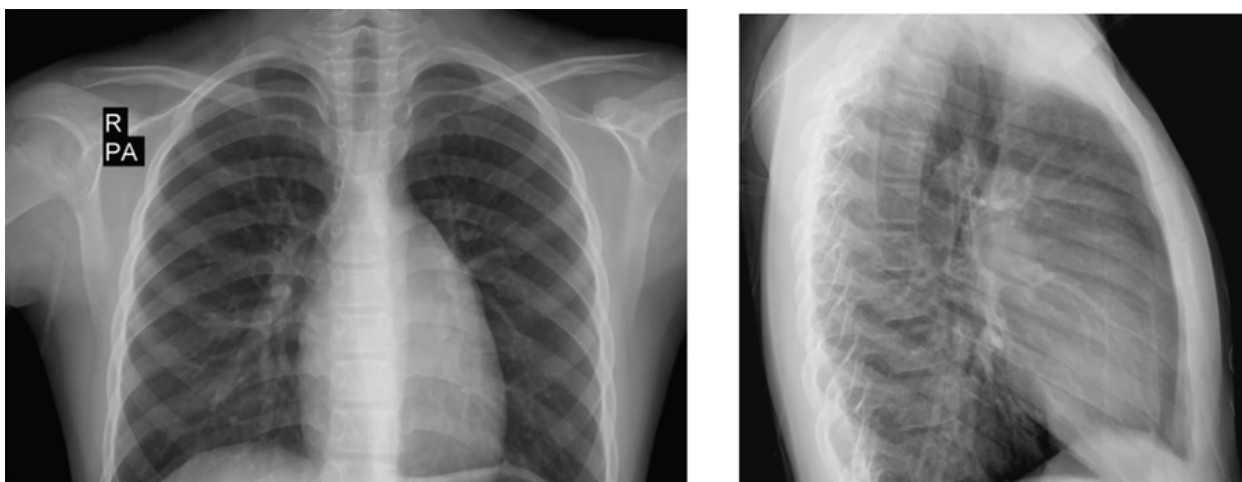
Chest X-Ray (AP-lateral view)
